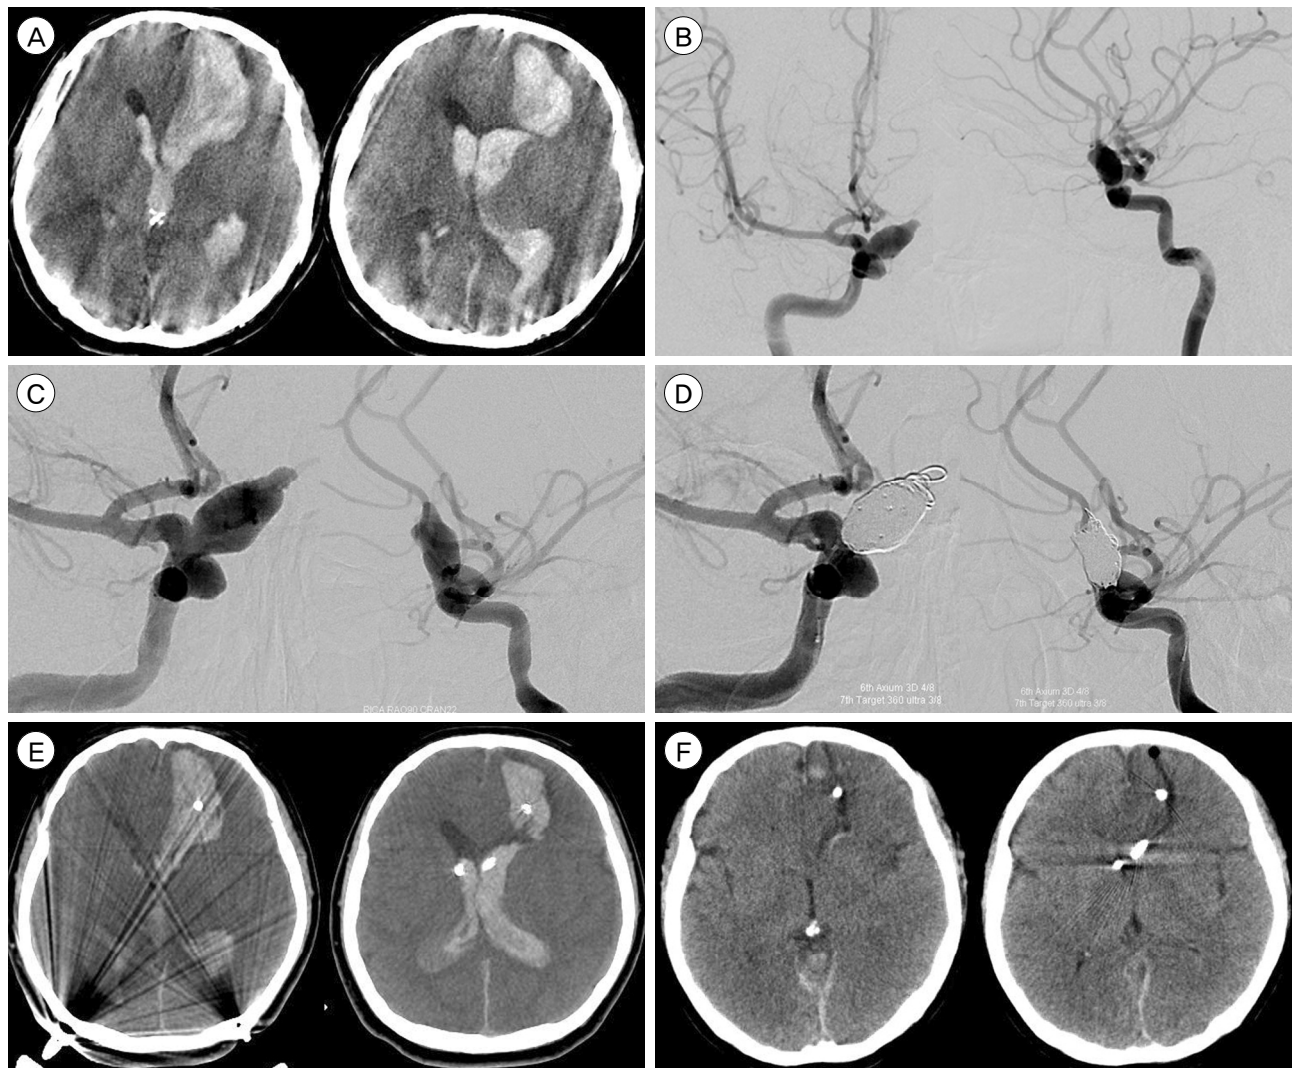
A 39-year-old female patient with ruptured right IC-ophthalmic aneurysm. (A) Brain CT scan revealed a diffuse IVH, and a large ICH in the left prefrontal area with an estimated volume of 56 mL. (B) Brain CTA and DSA revealed a 12 mm ruptured right-IC-Ophthalmic aneurysm. (C-E) She underwent endovascular coil embolization using 7 coils (C: preoperative, D: postoperative), which was followed by SRH and EVD (E: postoperative). (F) Seven days later, a brain CT scan revealed a significant decrease in ICH and IVH. CT = computed tomography; IVH = intraventricular hemorrhage; ICH = intracerebral hemorrhage; CTA = CT angiography; DSA = digital subtraction angiography; SRH = stereotactic aspiration of hematomas; EVD = extra-ventricular drainage.
